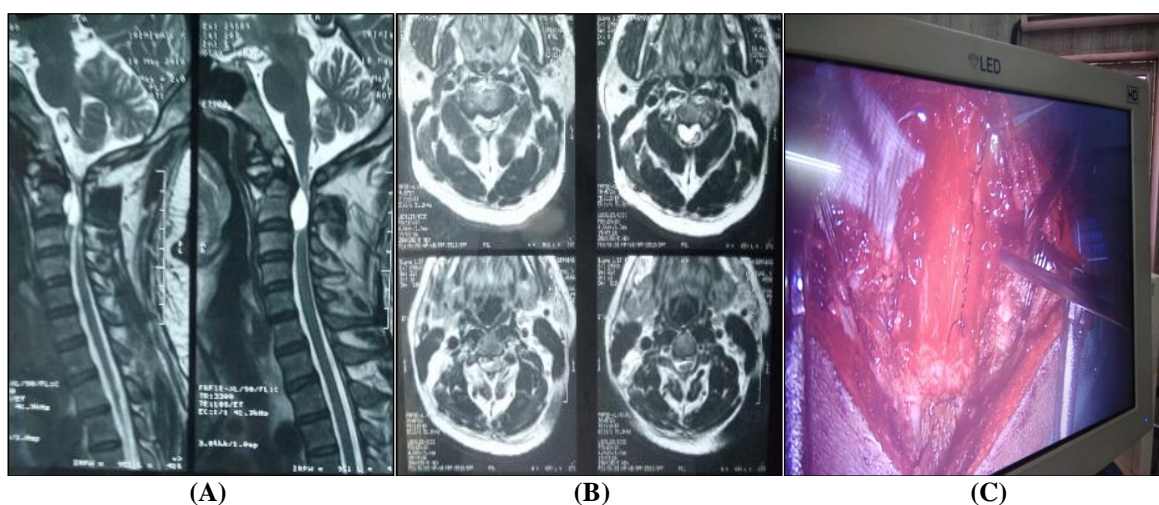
Case 8. A 42-year-old male presented with a 1/2-year history of progressive weakness of all 4 limbs and numbness Rt upper & lower limb with urinary incontinence since 6 months. Sagittal (A) and Axial (B) T2-weighted MR images showing dorsal displacement of spinal cord. Surgical exploration revealed a ventral arachnoid cyst at C2-C3 level, which was completely resected (C)
